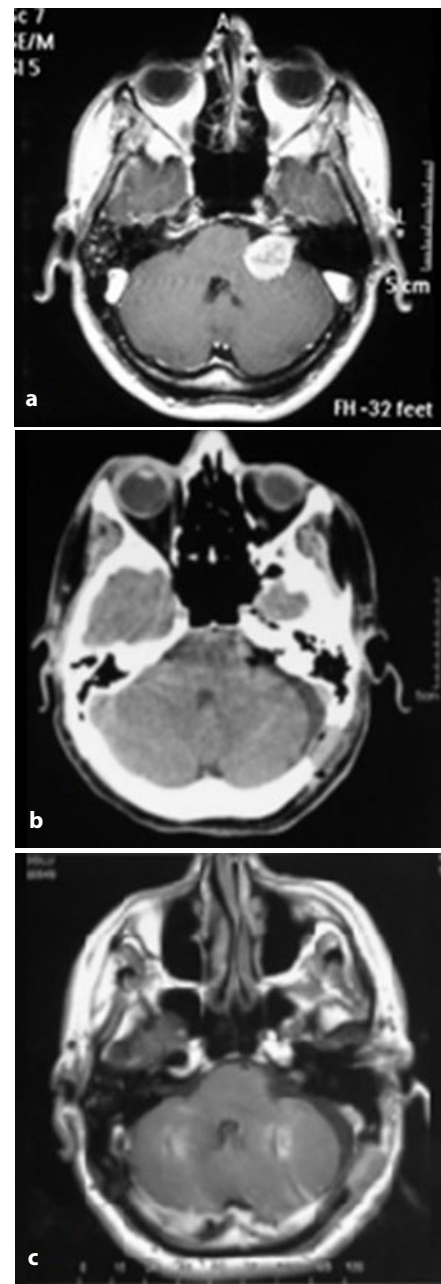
(a) Axial T1W MR with pre-operative contrast, (b) post-operative early period control brain CT, (c) axial T1W MR images with post-operative early period contrast are shown in a patient who underwent microsurgical resection. The tumor was completely removed.
